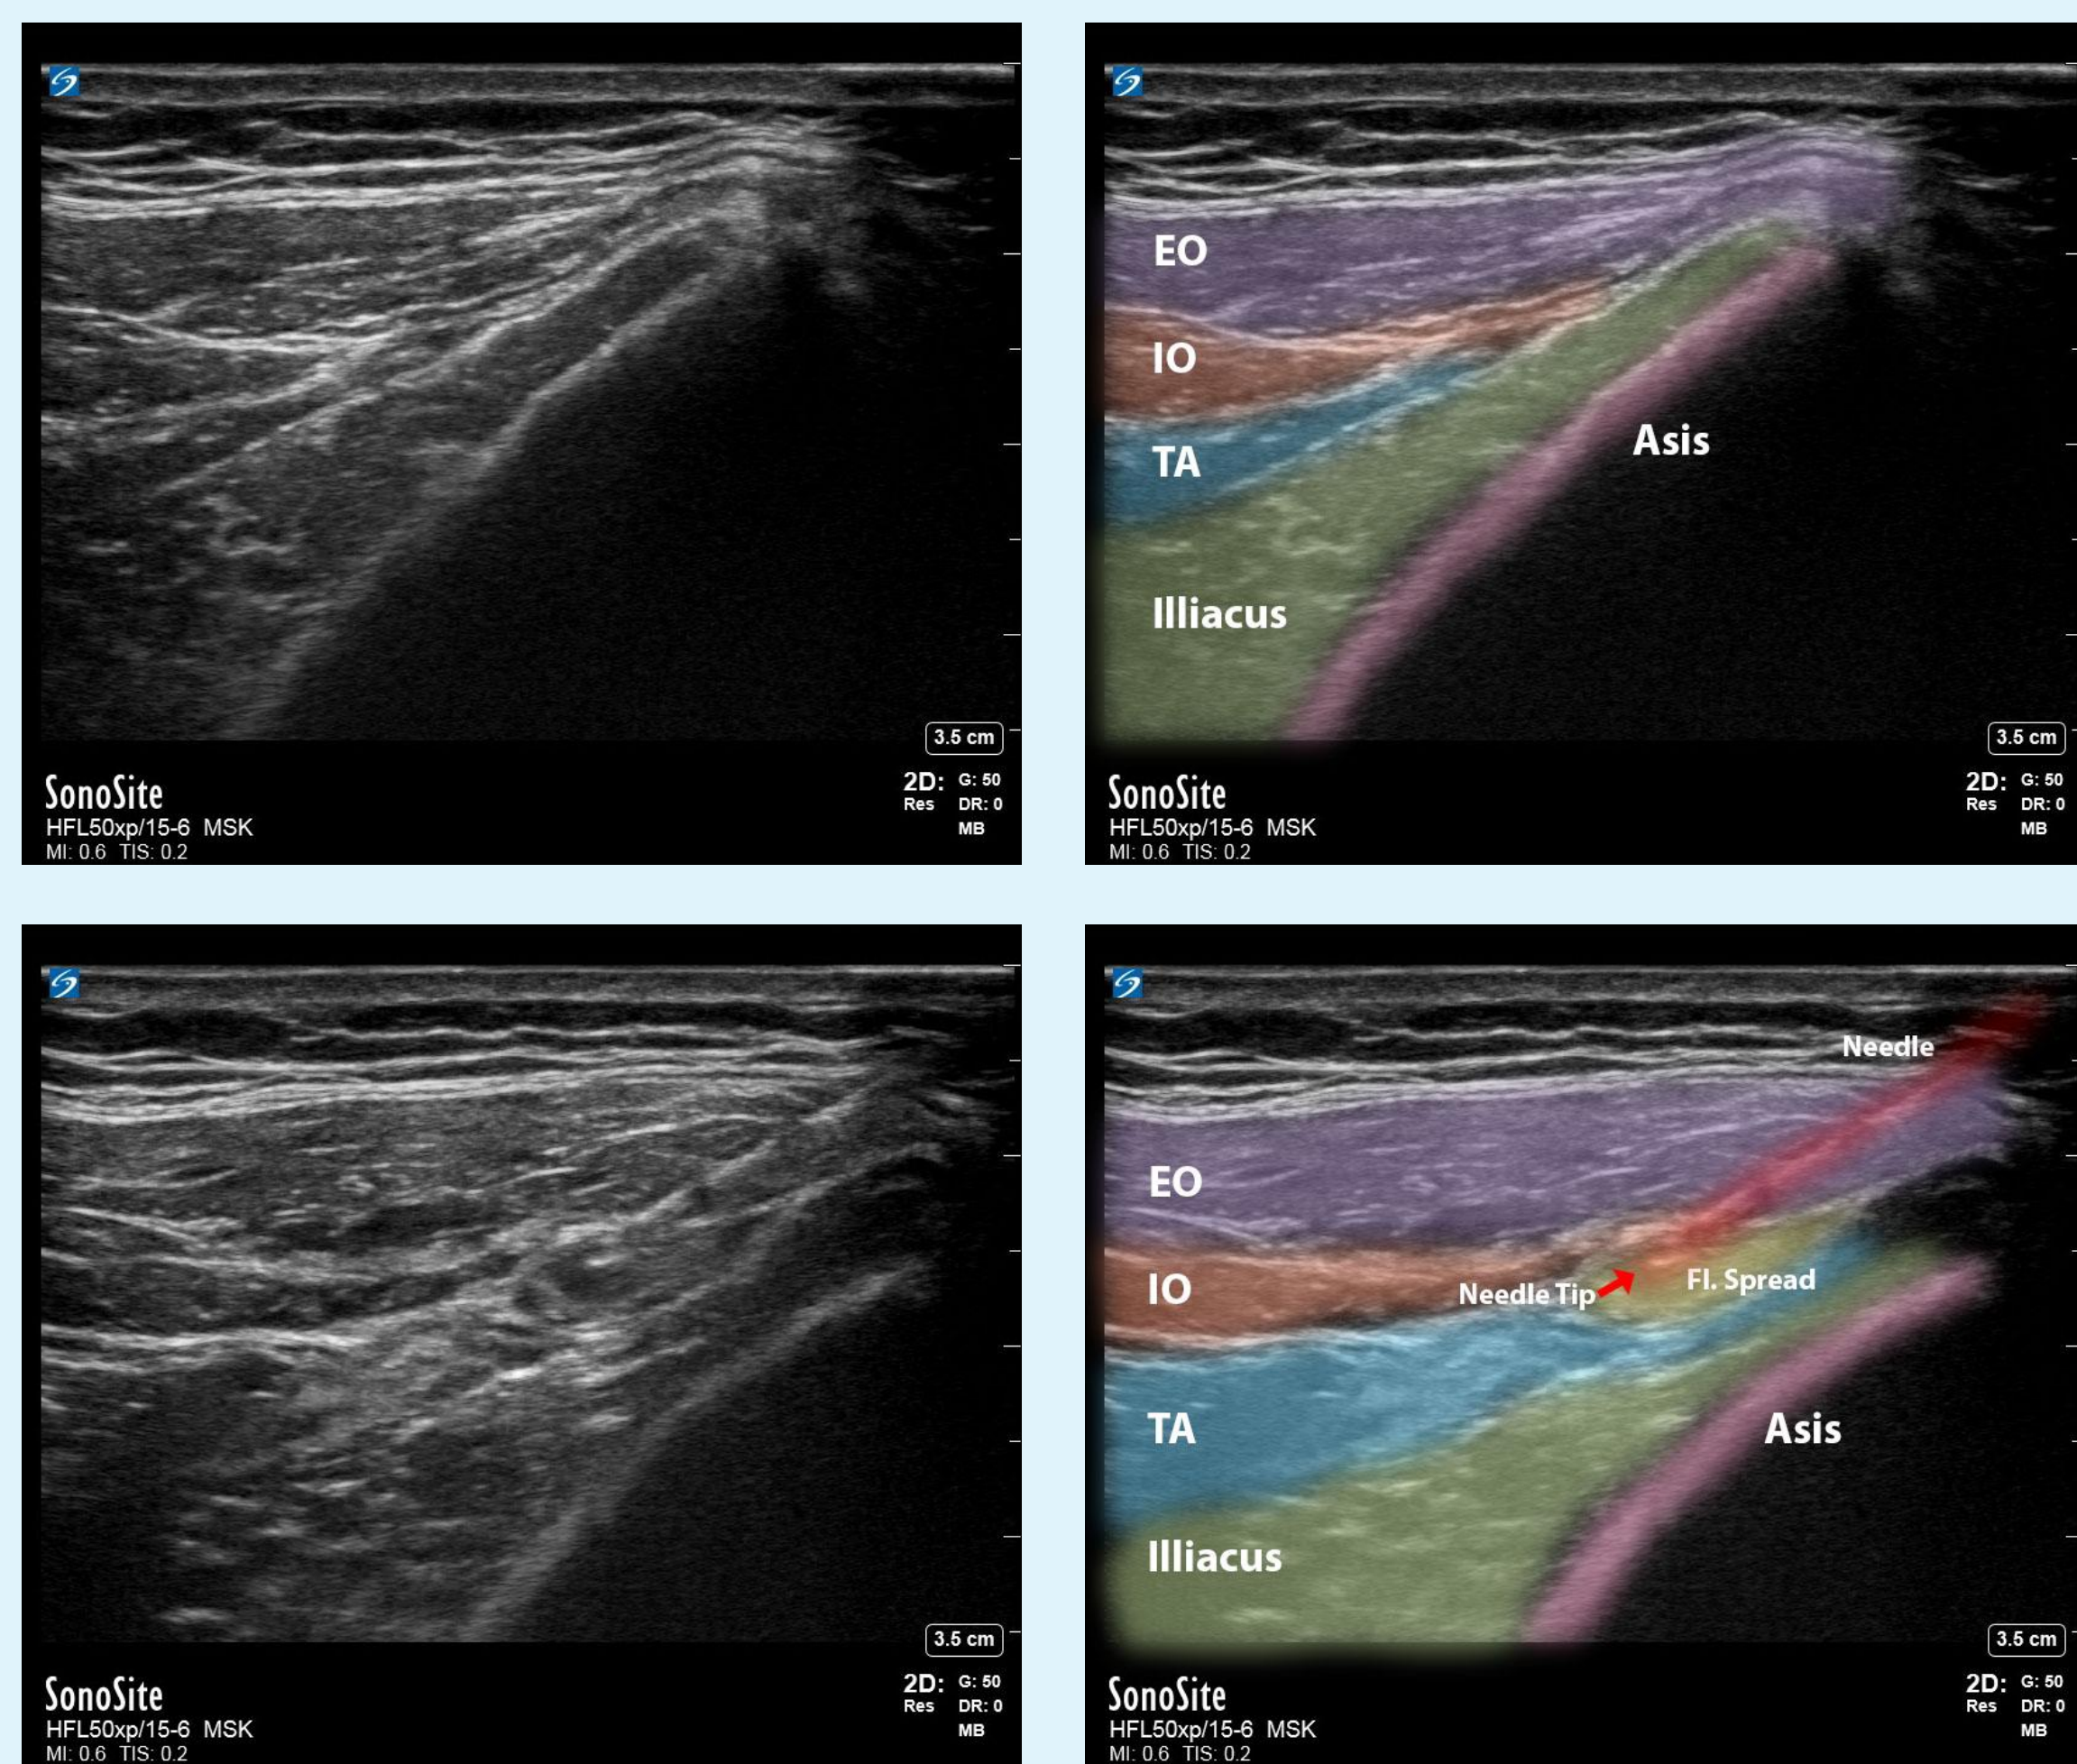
/b/c/d. 2a/b. Ultrasound imaging without/with false color overlay showing anatomy prior to II/IH block. 2c/d. Ultrasound imaging without/with false color overlay showing the anatomy during the block, with needle and needle tip visible. Abbreviations: EO = External Oblique; IO = Internal Oblique, TA = Transverse Abdominis
